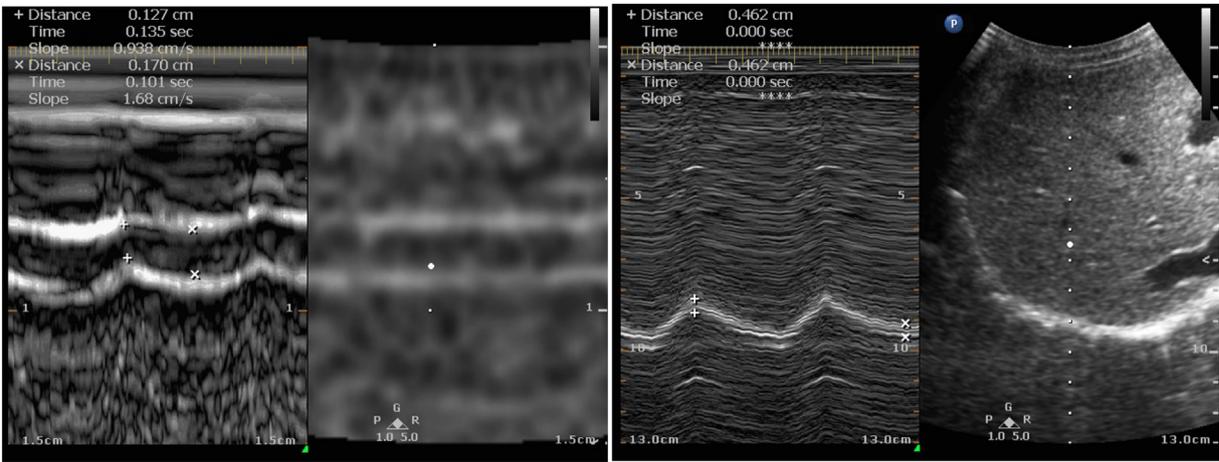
Diaphragmatic ultrasound; 2D and m-modes.
